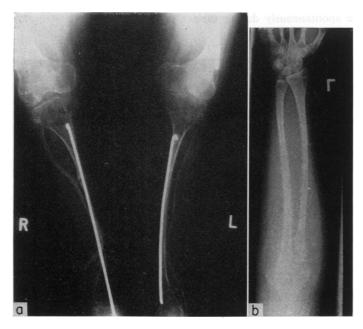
Osteogenesis imperfecta. The X-ray appearances are much more severe in the legs (a) than the arms (b) most probably as a result of immobilization of the legs due to fractures and surgery.
